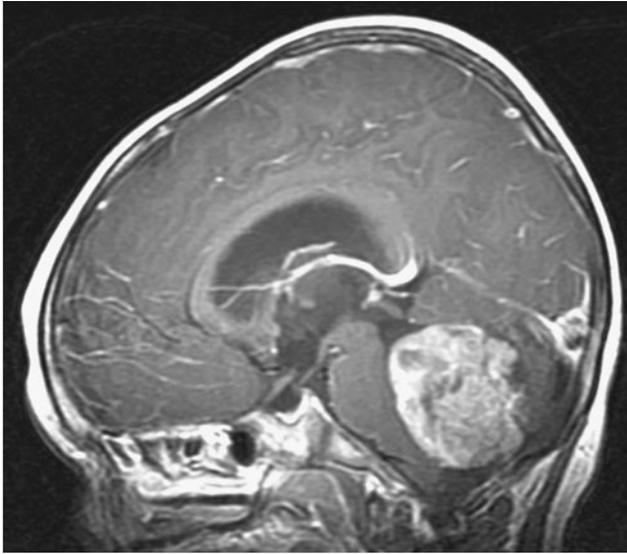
Medulloblastoma. Sagittal magnetic resonance image following the administration of contrast in a 2-year-old boy presenting with macrocrania and intermittent morning vomiting. The fourth ventricular medulloblastoma and resulting noncommunicating hydrocephalus are easily seen on this preoperative image.
